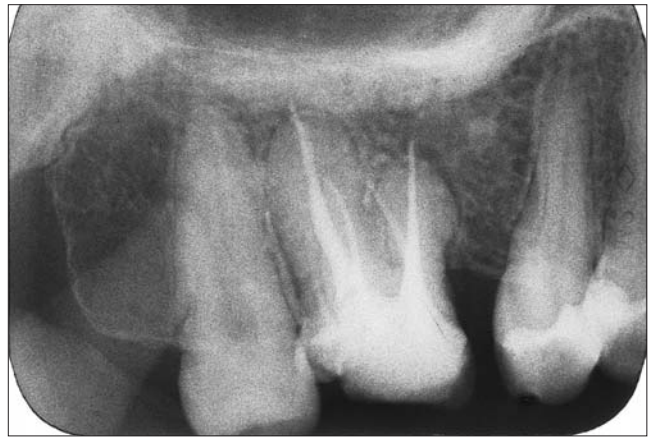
Postoperative radiograph showing obturation of bilateral 4-rooted maxillary second molar.
